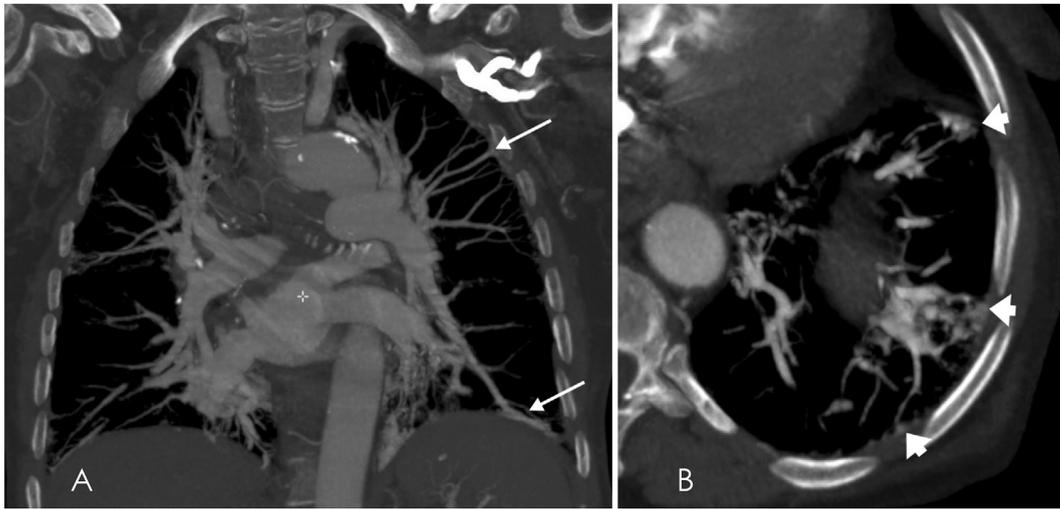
Chest computed tomography angiography with maximum intensity projection in (A) oblique coronal view showing dilation of peripheral lung vessels extending to the sub-pleural region with typical non-tapered aspect (white arrow); (B) transversal view zoomed on the basal region of the left lung showing dilated distal lung vessels extending to the pleura (white arrowheads) with subpleural opacities resembling telangiectasia.
